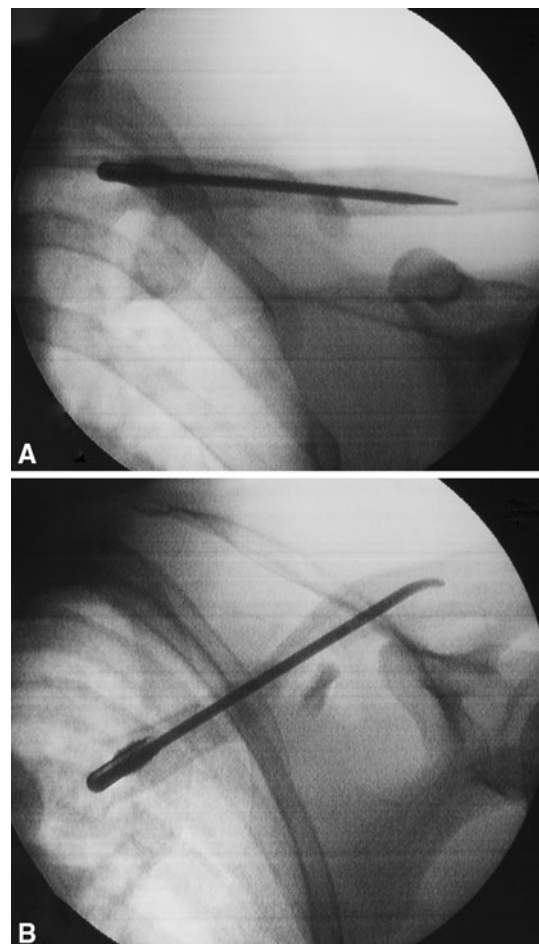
Intraoperative (A) AP and (B) oblique radiographs show a TEN with an end cap. TEN = titanium elastic nail.
